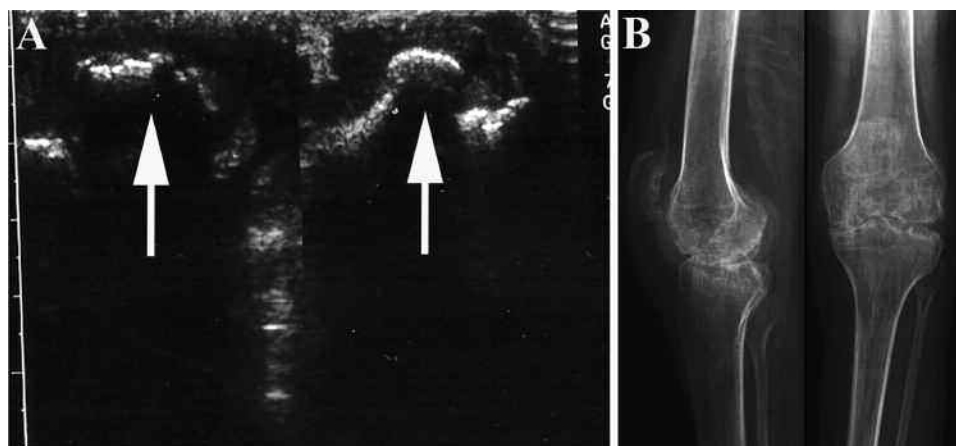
Representative images of ultrasonographic (US) and radiological findings of the knee in patients with hemophilic arthropathy. A. Bone remodeling with osteophytes and calcifications (arrows) of medial femoral condyle by US. B. Cartilage alterations, bone remodeling, calcifications, and osteophytes are shown by radiograph.
